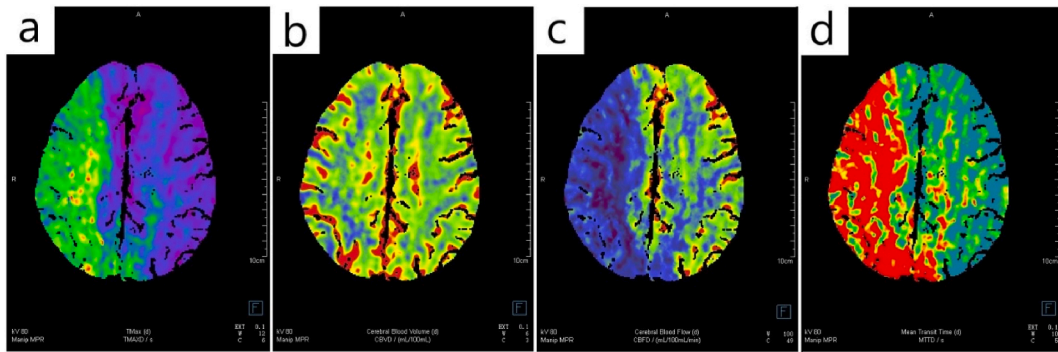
Preoperative brain CTP images of the same patient as Fig. 2. Tmax of the affected side (right) was 4.97s, and Tmax of the contralateral side was 2.11s (a). CBV of the affected side (right) was 3.05mL/100 mL, and CBV of the contralateral side was 3.40 mL/100 mL (b). CBF of the affected side (right) was 23.41 mL/100 mL/min, and CBF of the contralateral side was 54.23 mL/100 mL/min (c). MTT of the affected side (right) was 9.45s, and MTT of the contralateral was 4.35s (d). CTP = computed tomography perfusion, Tmax = time to maximum, CBV = cerebral blood volume, CBF = cerebral blood flow, MTT = mean transit time.
